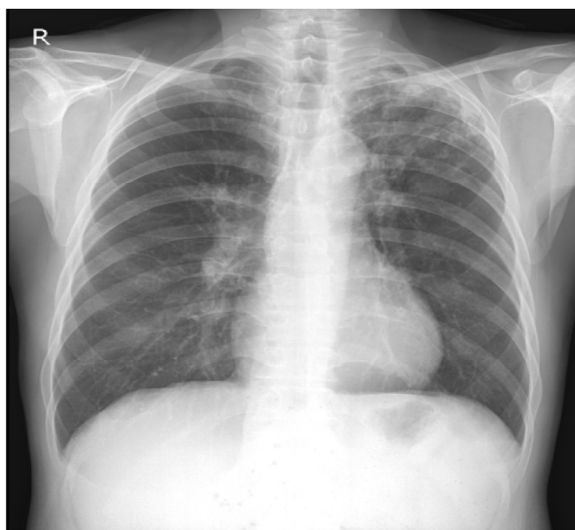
Chest X-ray. Nonspecific finding, No abnormality is seen.
